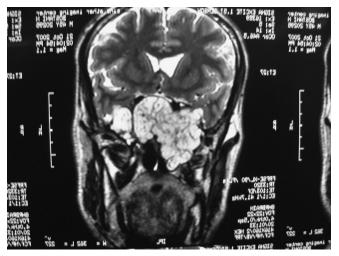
Magnetic resonance imaging view reveals hyperdense, lobulated, huge tumor in the anterior cranial base.
